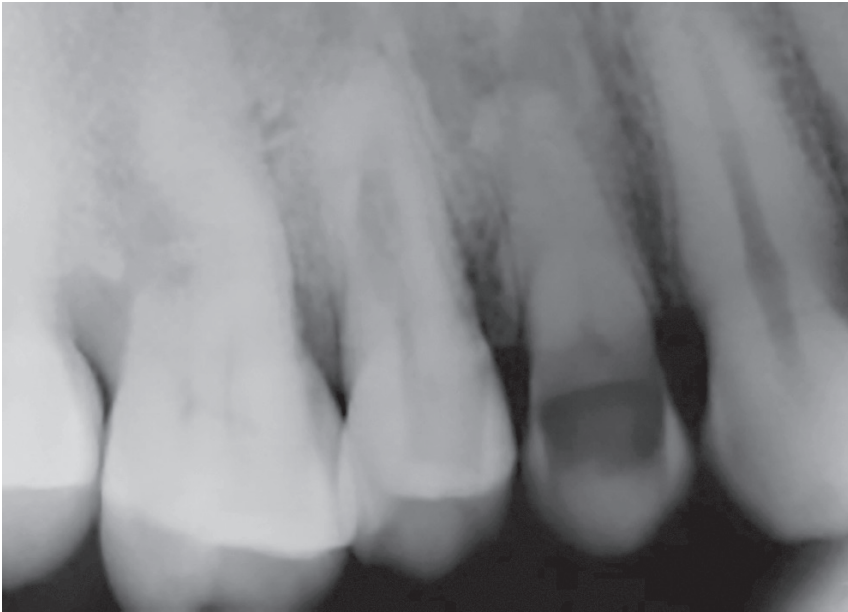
Diagnostic Radiography in 04/2017.
